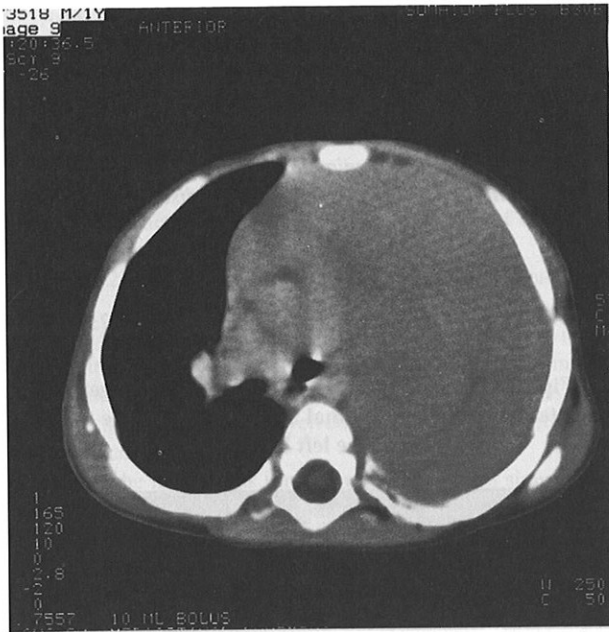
CT scan showing complete occupation of the left hemithorax by the mediastinal mass and hypoplasia of the left lung.
